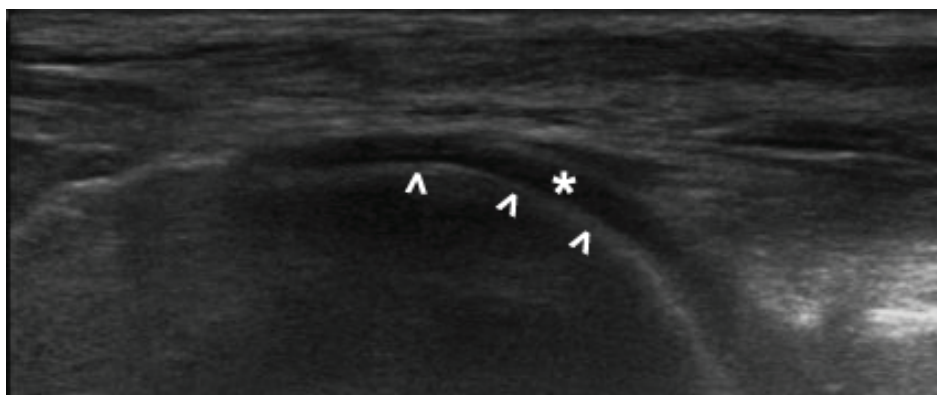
(below): Representative ultrasound image of the talus with the cartilage
